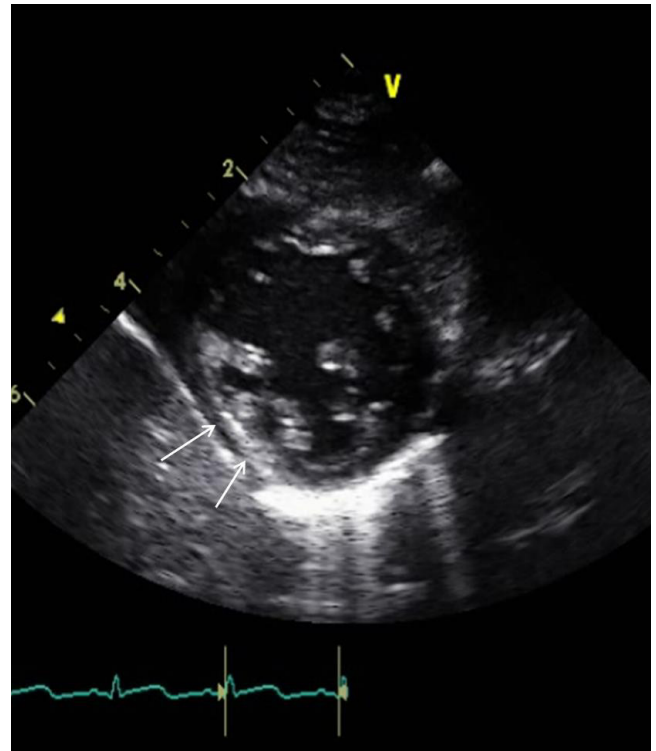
Transthoracic echocardiography in the parasternal short-axis view shows bright echogenicity and thinning of the posterior wall of the left ventricle (arrows) suggestive of an ischemic change.
